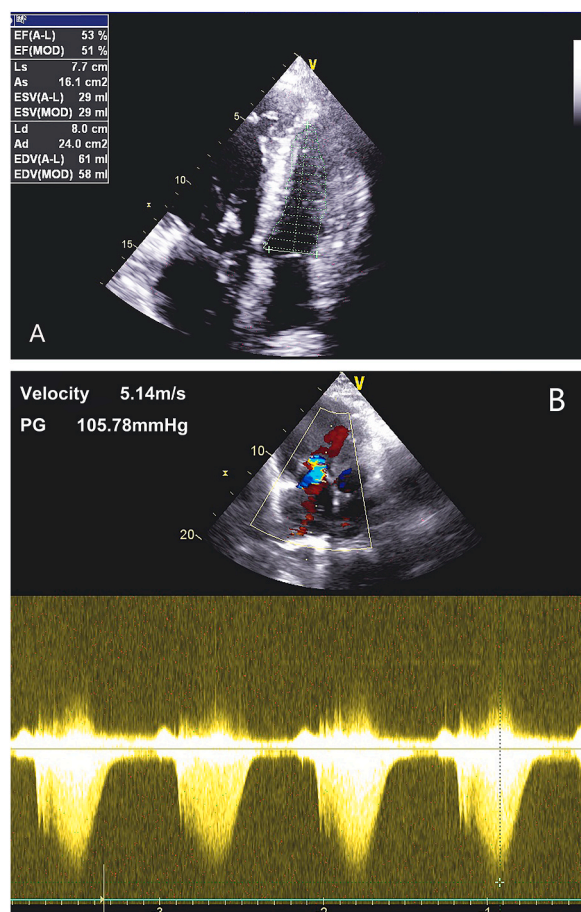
Follow-up echocardiography in 2016. Transthoracic echocardiography demonstrated a markedly enlarged right atrium and right ventricle (A), along with tricuspid regurgitation, and an estimated pulmonary artery systolic pressure of 120 mm Hg (B).
